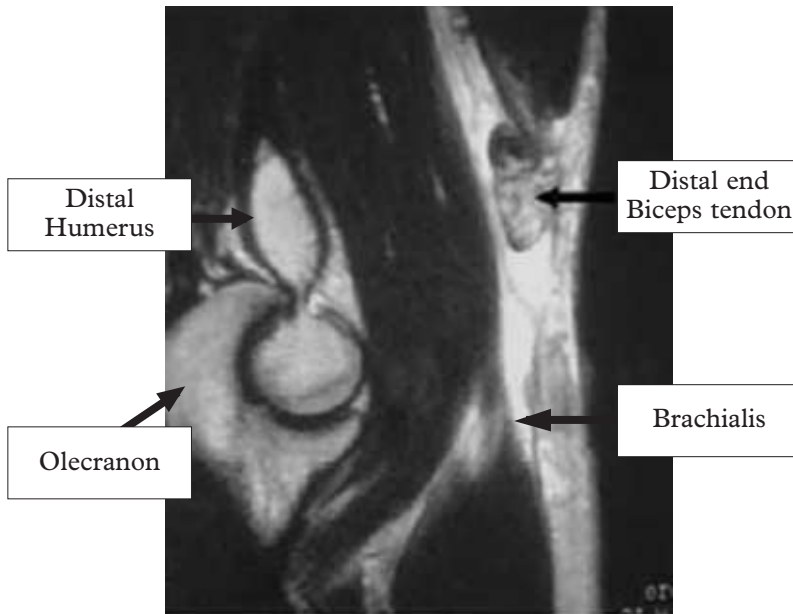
MRI ruptured biceps tendon.
